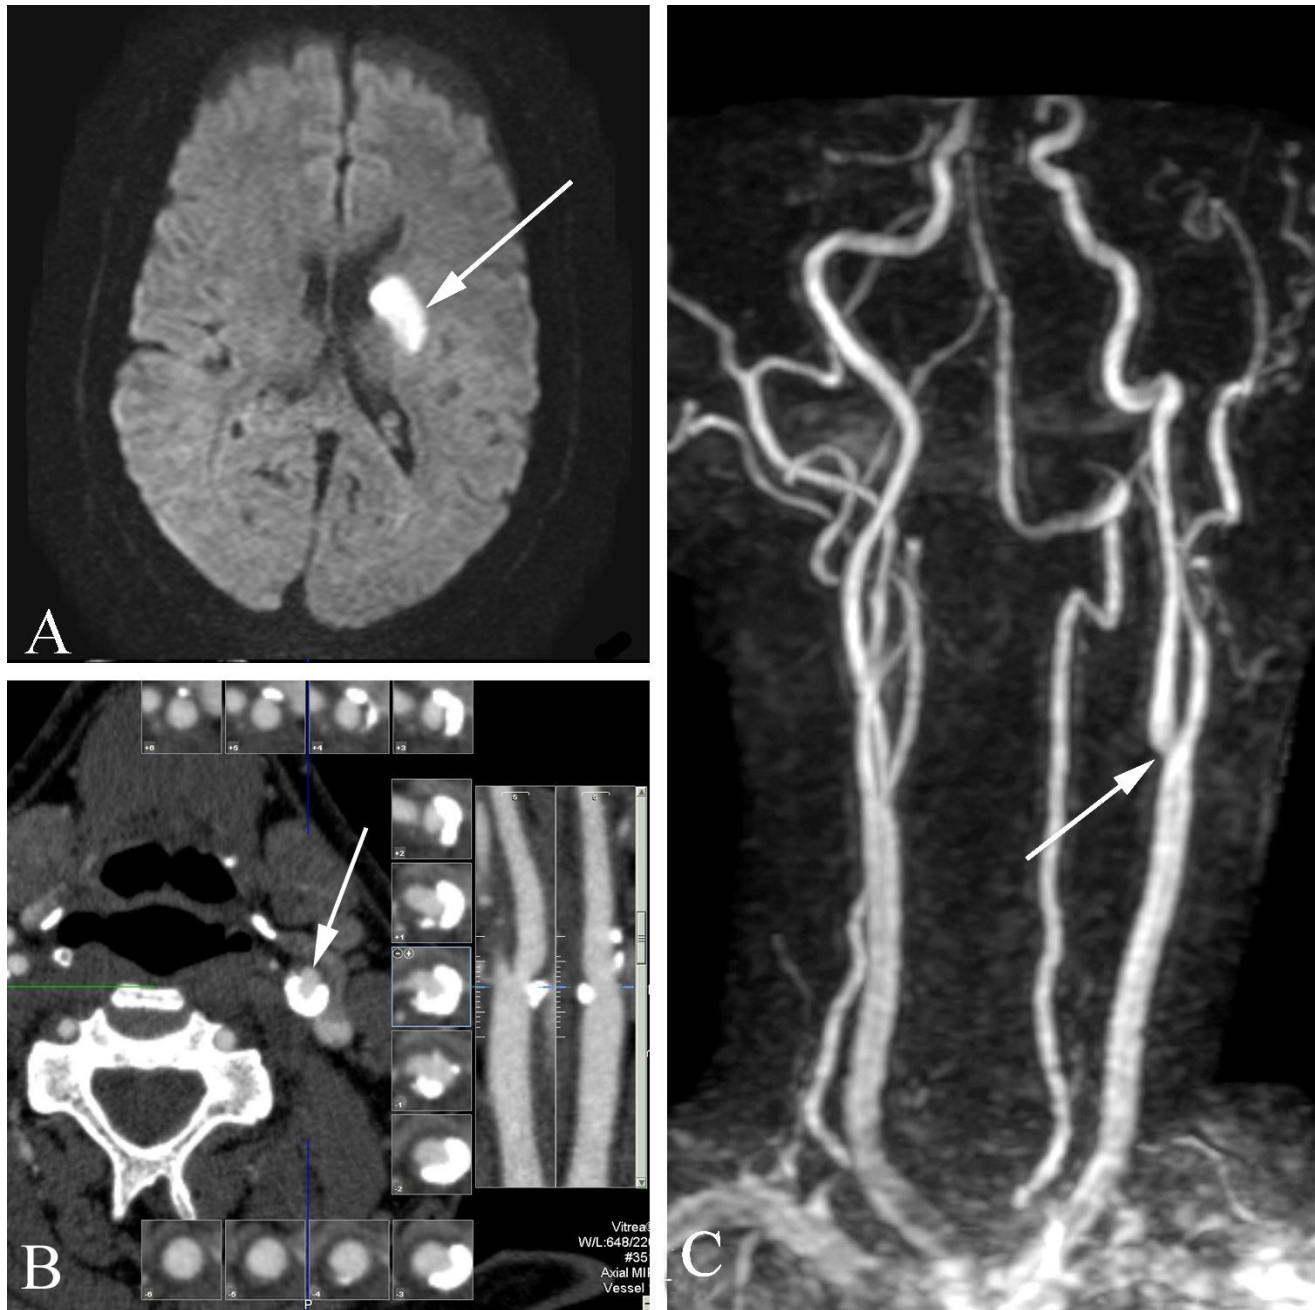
Less than 50% carotid artery stenosis in a 58 year old man with transient facial droop and aphasia. A. Axial diffusion weighted MR image demonstrates restricted diffusion in the left hemisphere adjacent to the ventricles (arrow) compatible with an acute cerebral infarction. B. CT angiogram through the left carotid shows an axial slice at the level of the proximal internal carotid artery (arrow) with axial images arrayed around the vessel from proximal to distal, with reconstructed long axis views at perpendicular projections on the right side of the panel, showing less than 50% stenosis. C. 3D maximum intensity projection MR angiogram confirms less than 50% stenosis of the left internal carotid artery.
